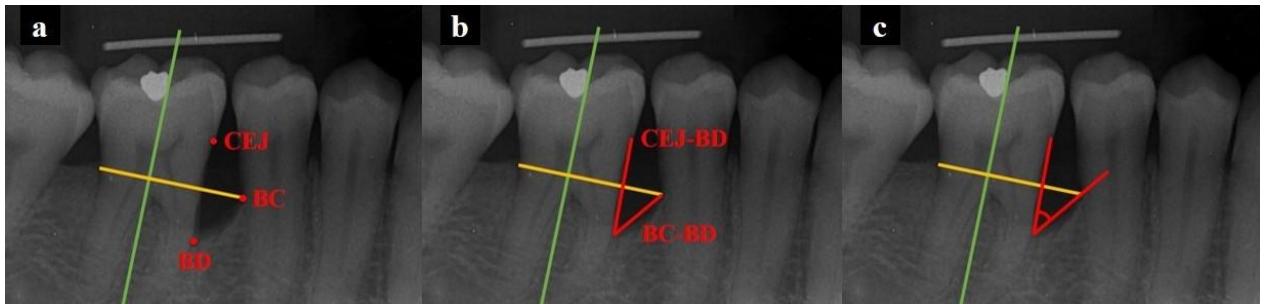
Radiographic evaluation of intrabony defect. a) Auxiliary lines and anatomical references, CEJ-cement-enamel junction, BC-bone crest, BD-basis of the defect. b) Anatomical distances, CEJ-BD and BC-BD. c) Defect angle.
